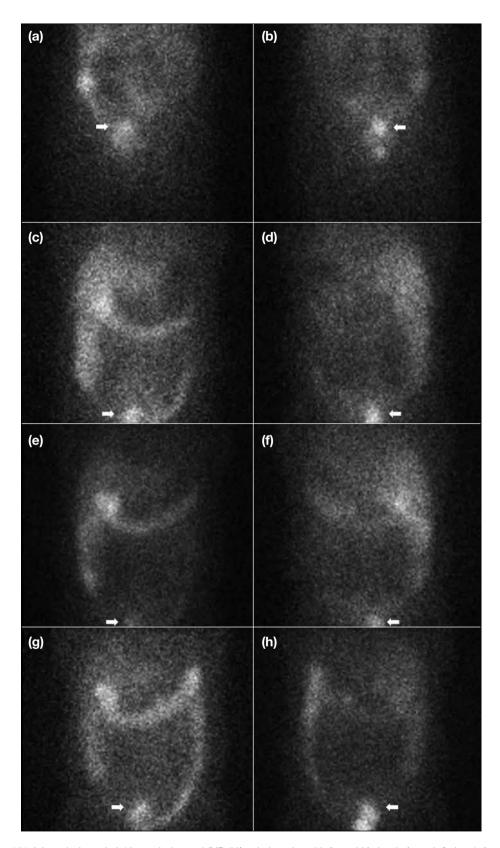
lodine-131 6-beta-iodomethyl-19-norcholesterol (NP-59) scintigraphy with (a and b) day 3, (c and d) day 4, (e and f) day 5, and (g and h) day 7 anterior and posterior planar images of abdomen and pelvis. There was suboptimal coverage of the pelvis on day 5 images owing to initial assumption of pelvic activity (arrows) as physiological bowel activity. Day 3, 4 and 7 images raised the suspicion of possible abnormal focal increase in right adnexal NP-59 uptake (arrows), requiring additional single-photon emission computed tomography-computed tomography images for confirmation.
